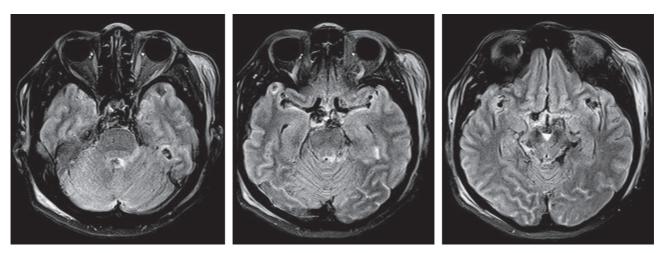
Brain magnetic resonance image (MRI); The interpeduncular cisternal hemorrhage was observed in MRI.
